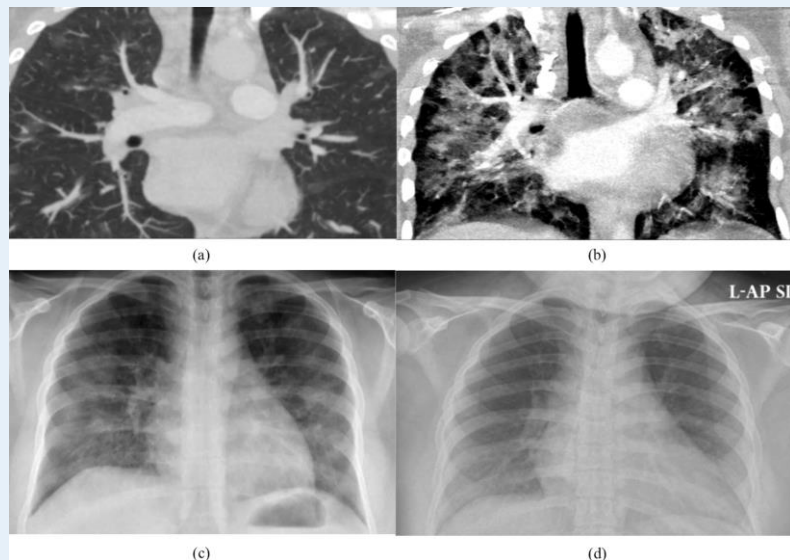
Various extents of bilateral lung ground glass opacities ranging from mild (a) to severe (b) in lung windows of contrast CT thorax in repeated admission of this patient with sub-therapeutic INR level and clinically dyspnea and hemoptysis. The bilateral lung opacities seen in the chest X-ray on admission (c) showed subsequent resolution (d) in all admission after titrating the dose of warfarin reaching the therapeutic range of INR value.
